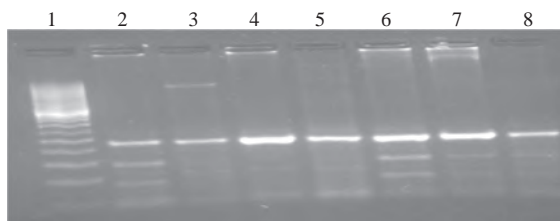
Lane-2, 6, 7 and 8 showing CT (3 fragments: 228 bp, 142 bp and 86 bp) of rs10156191 SNP. Lane-3, 4 and 5 showing CC (1 fragment: 228 bp). Lane-1 50 bp DNA ladder.
